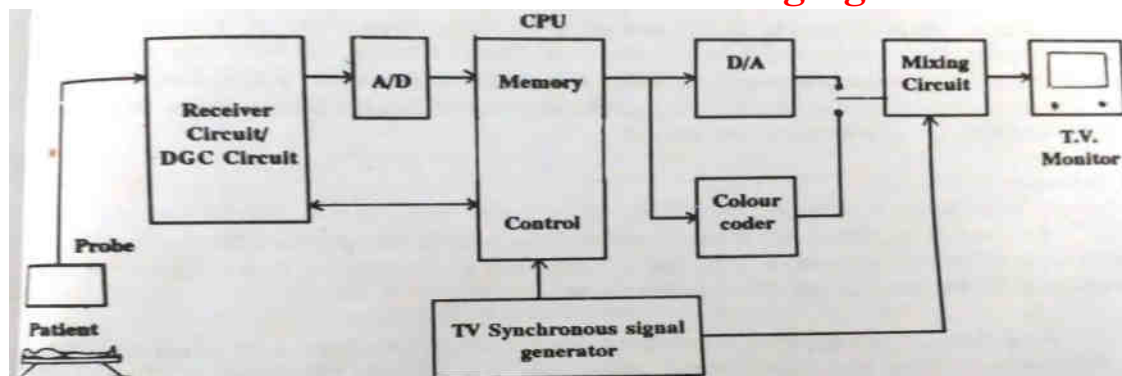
Digital real time ultrasonic scanner
